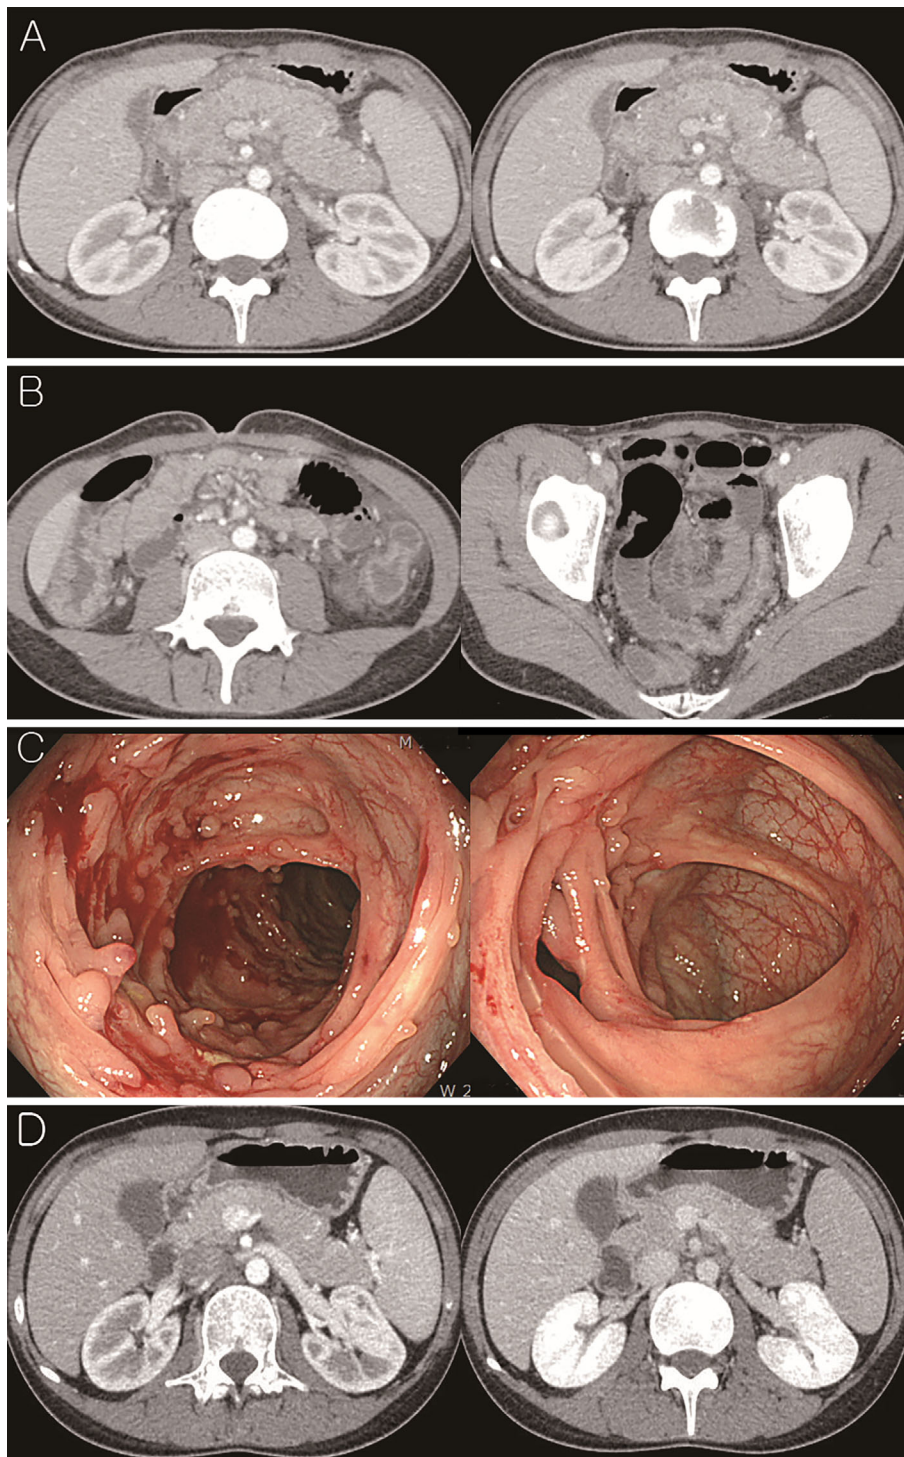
Axial abdominal computed tomography. A: Diffuse enlargement of the pancreas with a peripheral rim of low attenuation and minimal peripancreatic fluid collections. B: Diffuse colonic wall thickening with slight enhancement from the cecum, including terminal ileum, to hepatic flexure and sigmoid colon. C: Longitudinal ulcers with a cobble stone appearance, pseudopolyps, and patulous ileocecal valve were identified during colonoscopy. D: Diffuse enlargement of the pancreas with peripancreatic fluid collection improved after 2 weeks of treatment with steroids.
